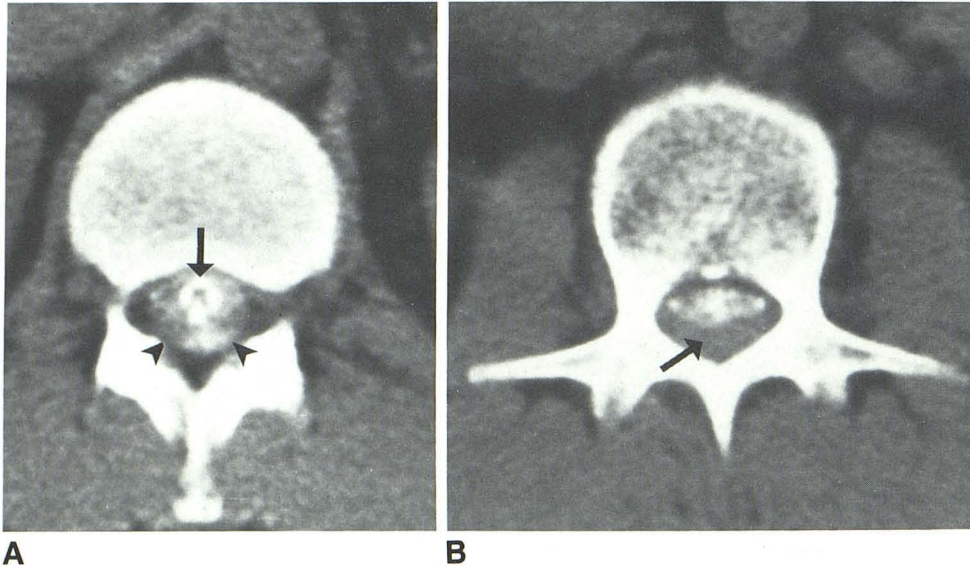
A, Case 1: partial subdural injection of conus medullaris level postmetrizamide myelography. The densely opacified subarachnoid space (*arrow*) has been concentrically narrowed by partial subdural injection of metrizamide. The lower density of the subdural compartment is probably a result of cerebrospinal fluid mixing with metrizamide. The outer dural margin and epidural fat are both normal. B, Postmetrizamide CT section at the L1 level shows opacified subarachnoid space displaced anteriorly by "soft-tissue mass" (*arrow*), which is actually an extension of subdural mixture of cerebrospinal fluid and metrizamide.
